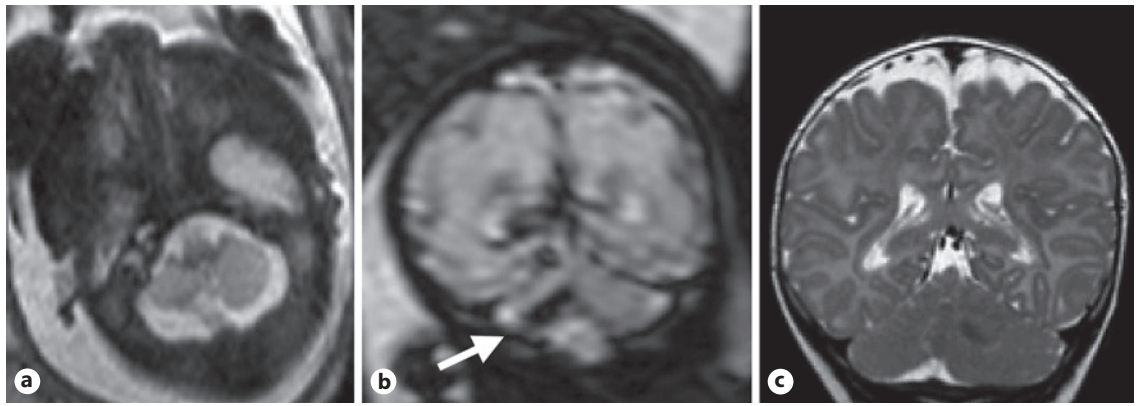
Case 3. Asymmetrical cerebellar hemispheres resulting from right hemispheric hemorrhage; normal vermis. Ultrasound at 30 weeks of gestation demonstrated a small right cerebellar hemisphere (not shown). a, b MRI at 30 weeks of gestation. a T2-weighted axial slice showing a small right cerebellar hemisphere with an irregular border. b Gradient echo T2 coronal slice showing
